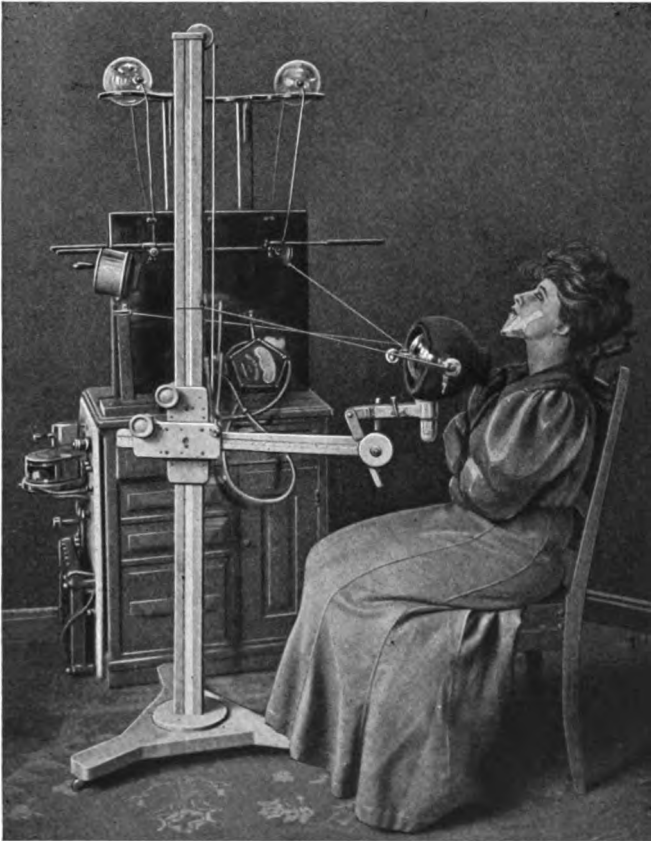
X-ray treatment of exophthalmic goiter. Brickner's tube-stand. Friedlander shield. Point of chin still further protected by x-ray metal.
